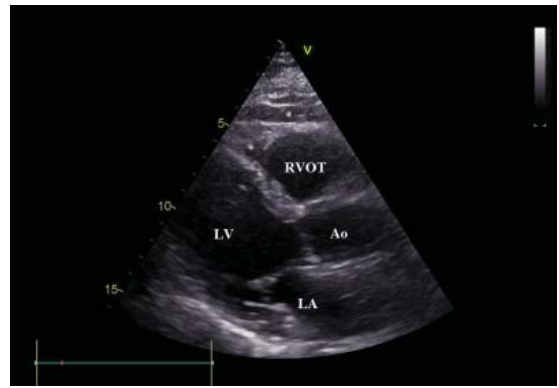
Echocardiographic measurement of epicardial adipose tissue is shown in the image. Astral between two lines shows epicardial adipose tissue area. LV=Left ventricle, LA=Left atrium, Ao=Aorta, RVOT=Right ventricle outflow tract.
